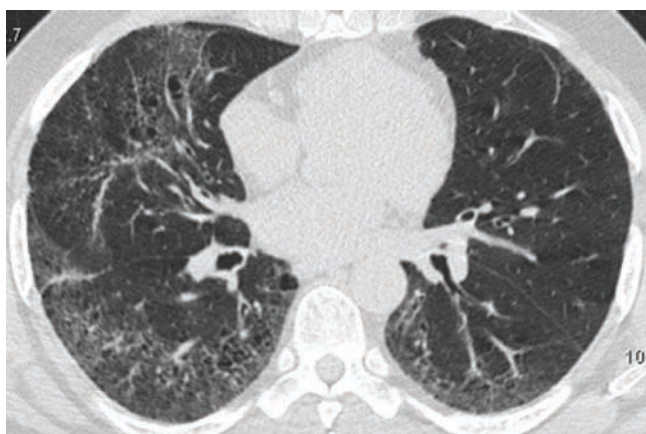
HRCT – nonspecific interstitial pneumonia
